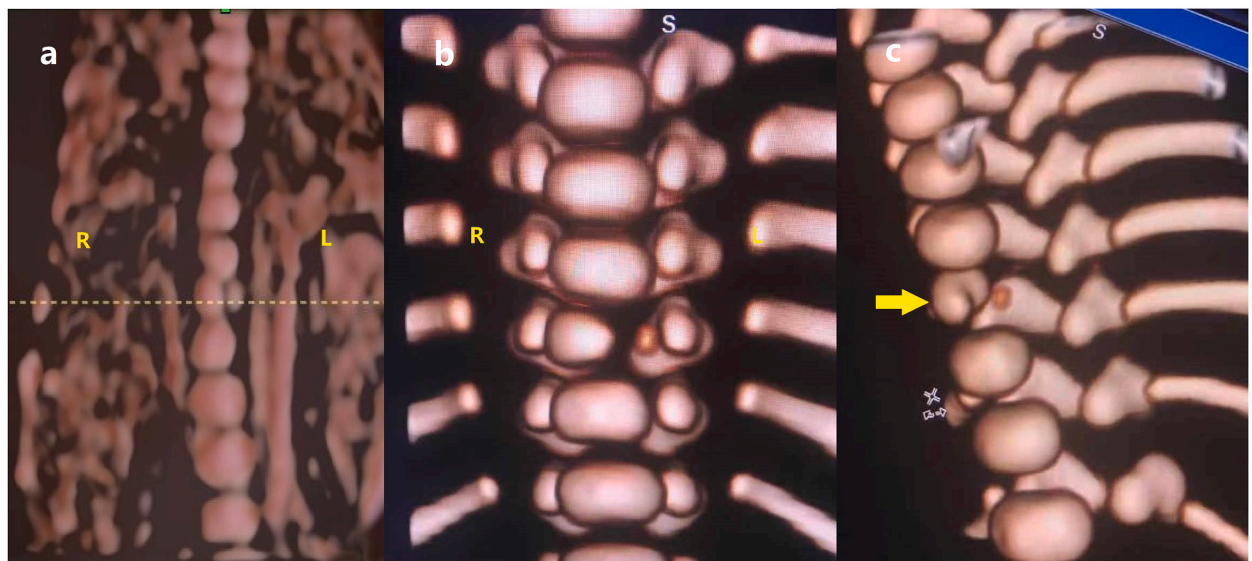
(a) Reconstructed coronal view obtained via 3D ultrasound while the fetus was in a supine position. Two ossification centers of the T9 vertebral body are visualized and the left one appears to be smaller than the right one. (b) 3D CT coronal view. Two ossification centers of the T9 vertebral body are shown. (c) The 3D CT side view. The right half of the affected body was C-shaped (arrow).
